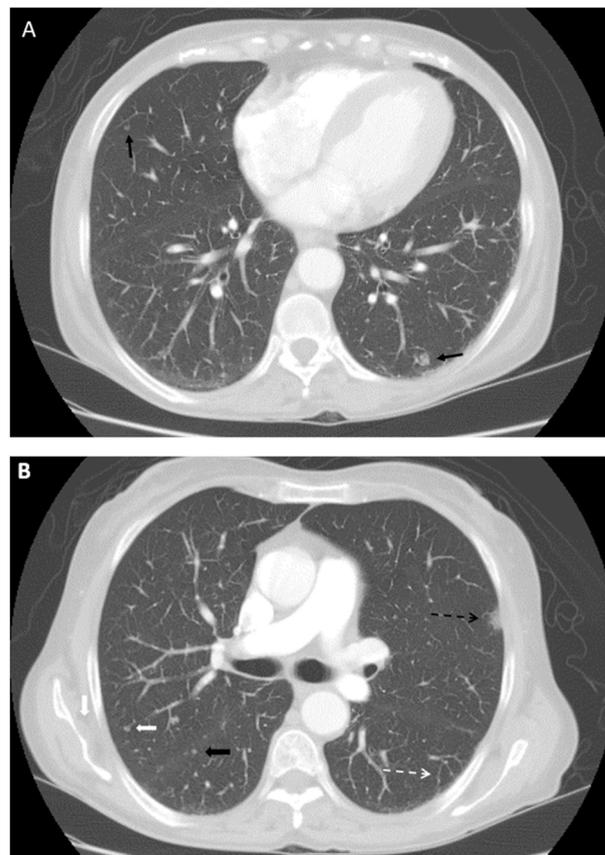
A, Axial section from chest CT performed after administration of intravenous contrast material and set to lung window demonstrates branching centrilobular nodules (black arrows) following blood vessels without associated air trapping. B, Axial section from the same chest CT as in panel A but at a more cranial level demonstrates the additional findings of nodules in a perilymphatic distributions along fissural pleura (solid black arrow) as well as focal ground glass opacity (black dashed arrow) and branching vasculature in the periphery (dashed white arrow). Further examples of centrilobular nodules with feeding blood vessels and without evidence of air trapping are likewise seen at this level (solid white arrows).
